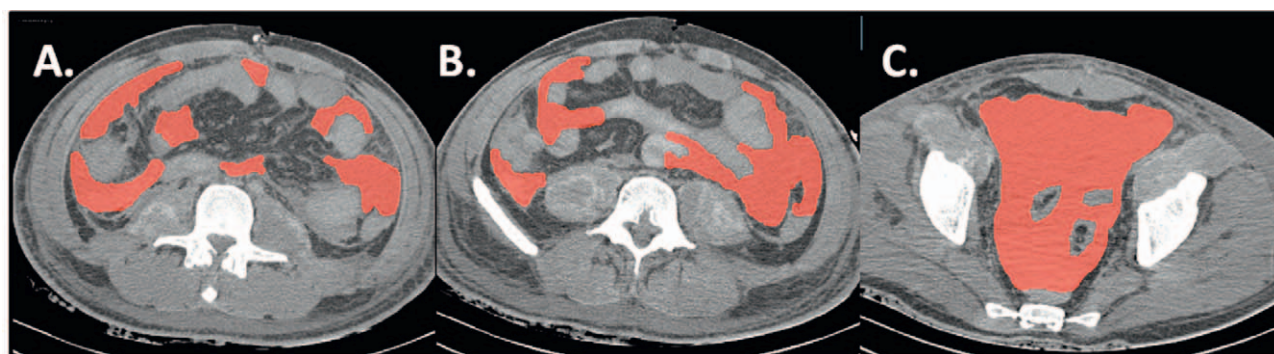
Axial computed tomography images of the abdomen at three distinct levels (A–C). The free abdominal blood is manually marked during segmentation procedure (red colored areas in A–C).
